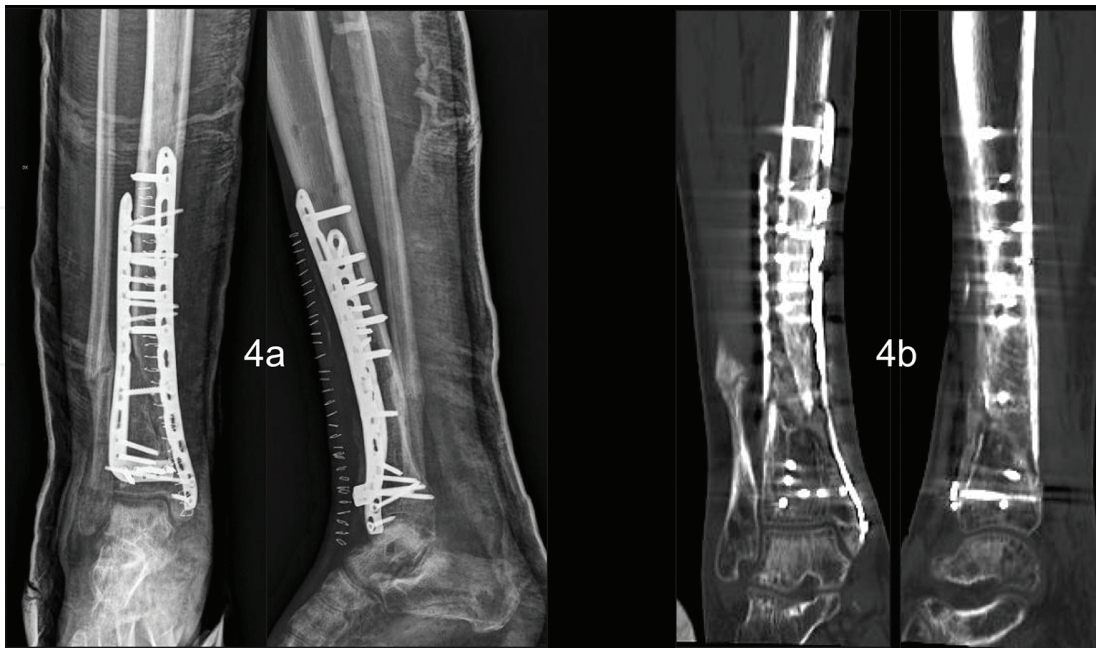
Clinical case 1—Man, 49 years, initial trauma following a motorcycle accident in which suffered exposed tibial pilon fracture, four ineffective treatments previously, comes to our attention (see X-rays and TC images) with a picture of septic non-union with serious bone loss and varus deformity, NUSS: 56 points.
